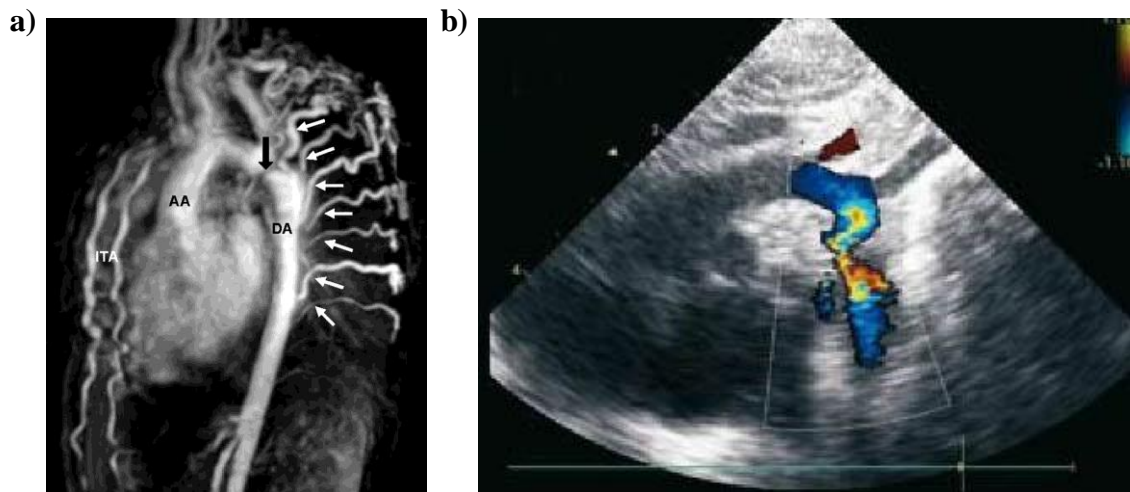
a) Magnetic resonance angiography of a CoA, with intercostals collateral arteries indicated by the white arrows (AA=ascending aorta, DA=descending aorta). Image taken from Ijland and Tanke, 2009; b) Echocardiography in an aortic arch with coarctation, showing a high velocity jet through the narrowing. Image taken from 58.
